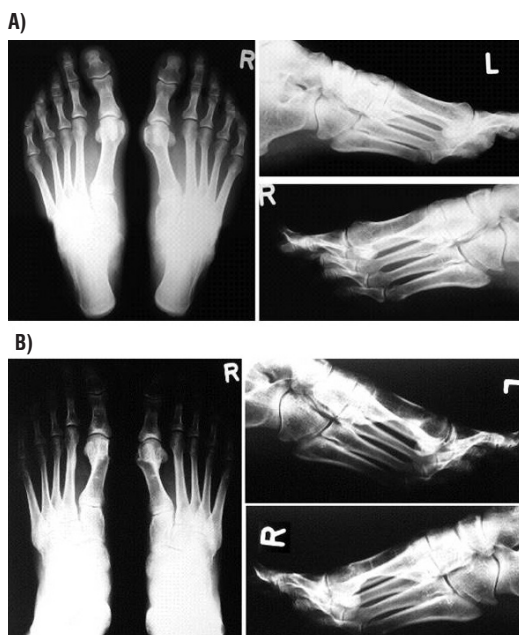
A) X-ray of both feet under load before corrective osteotomy of the first metatarsal bone (Patient No. 11, feet 11 and 12); B) X-ray of both feet under load 5 years postoperatively (Patient No. 11, feet 11 and 12) (both feet left, right left feet right above, right feet right below) (Kolundžić R., 2011)
